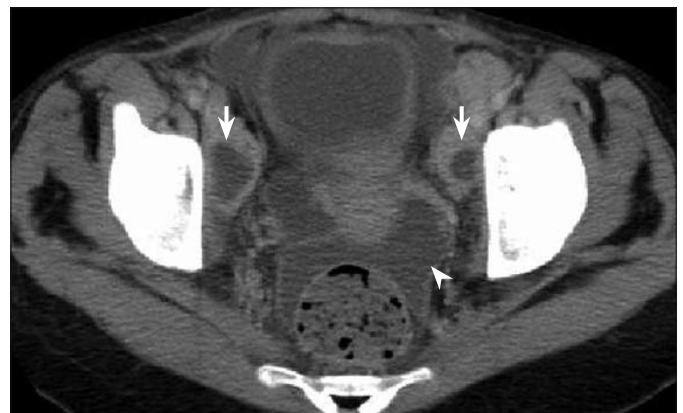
CT image of the pelvis demonstrates characteristic pathologic bilateral iliac lymph nodes (*arrows*). Ascites is also seen in the pelvis (*arrowhead*).
